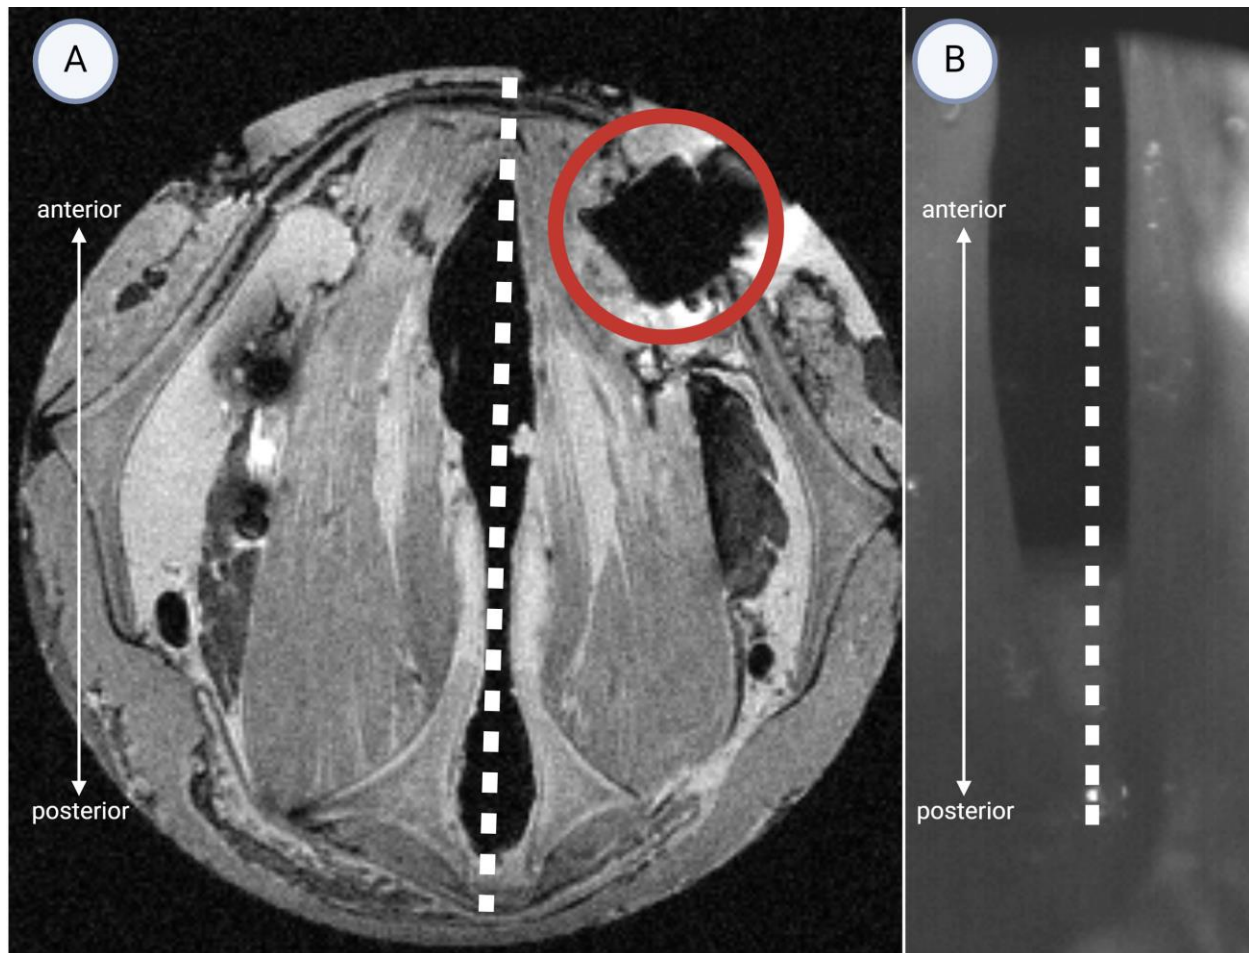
High-speed video and MRI images of implanted VF
